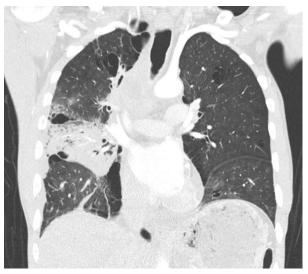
CT chest with contrast (coronal view) with right middle and lower lobe consolidation. Right paratracheal mediastinal peripherally enhancing fluid collection (2.2x1.3x2.5cm) with foci of gas concerning for empyema with mediastinal abscess.
